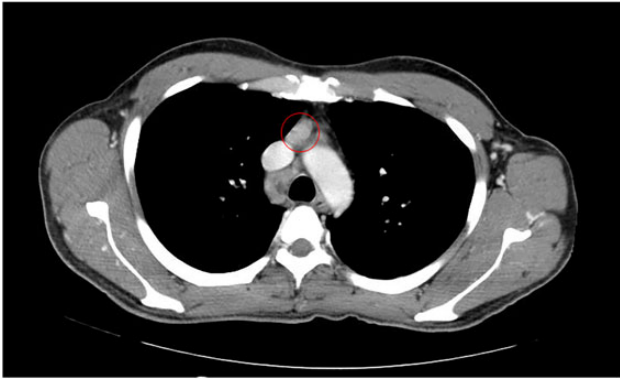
Chest computed tomography scan with contrast, showing mediastinal lymphadenopathy. Highlighted is one 12 × 21 mm enlarged lymph node in the right mediastinum.
